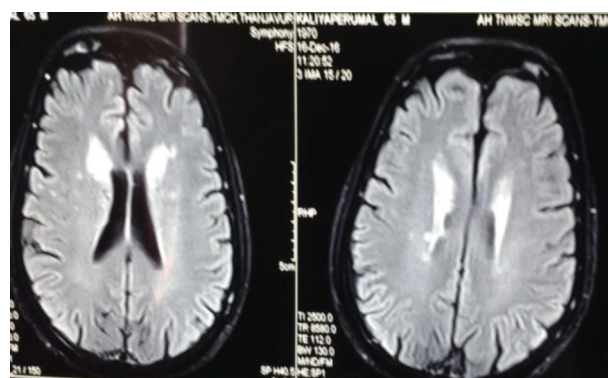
65 year old male patient presented with history of 1 episode of generalised tonic clonic seizures. There was past history of similar seizure episode 6 months back. MRI again showed periventricular hyperintensities on T1 weighted Images
